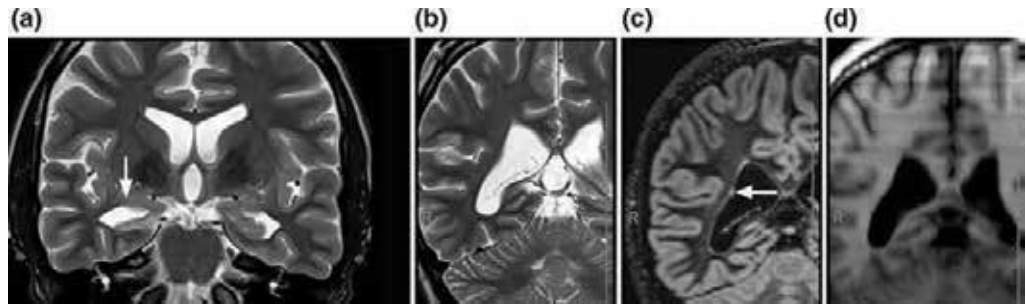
Oblique coronal T2 demonstrates obvious volume loss and laminar blurring of the right hippocampal head (*arrow*, panel a) consistent with right hippocampal sclerosis and right fornix atrophy (b). There is a small gray matter heterotopia in the lateral wall of the right lateral ventricle, best seen on the coronal double-inversion recovery image (*arrow*, panel c) compared to companion T2 and T1-weighted MRI (b and d).
